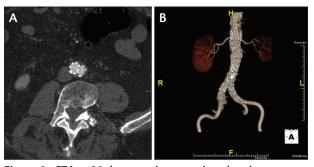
CTA at 30 days postintervention showing a satisfactory appearance of the distal aorta. Stent graft limbs are widely patent and not compressed (A). CTA at 30 days postintervention showing satisfactory appearance of the stent graft (B).
